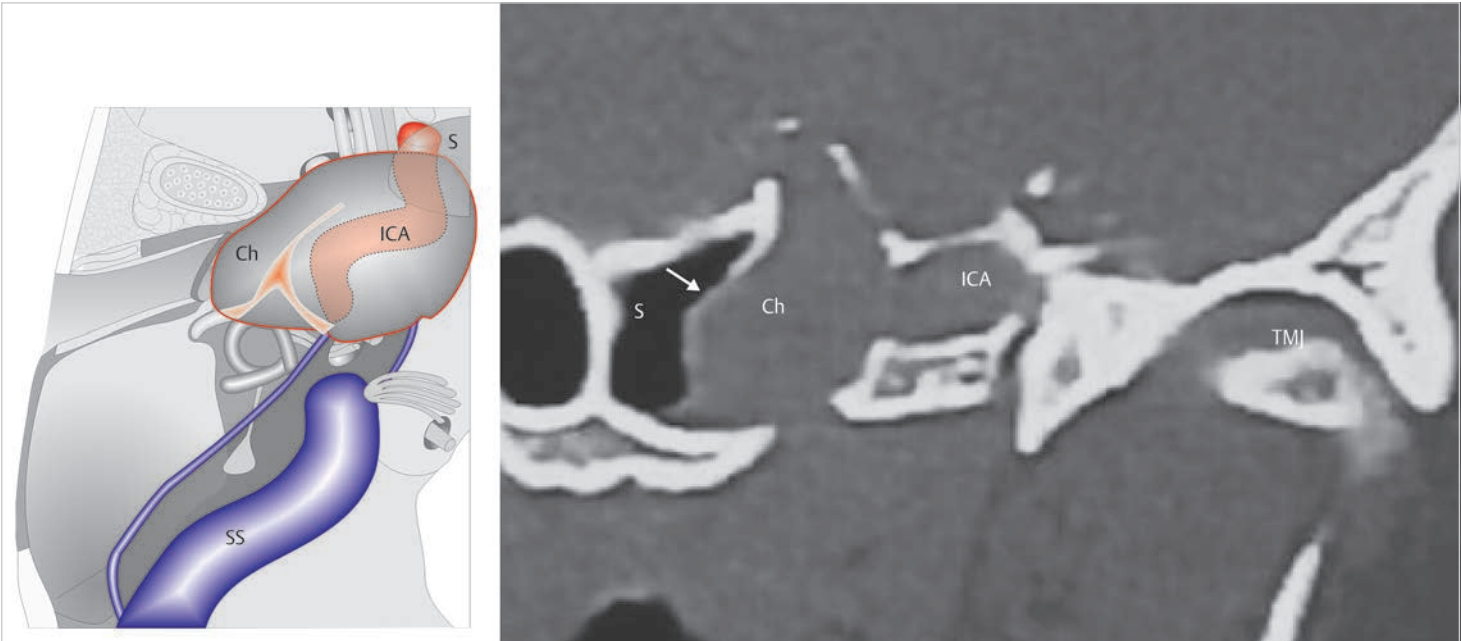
The coronal CT shows extension of cholesteatoma medially to the horizontal segment of the carotid artery reaching the left sphenoid sinus (*arrow*). ICA, internal carotid artery; Ch, cholesteatoma; S, sphenoid sinus; SS, sigmoid sinus; TMJ, temporomandibular joint.
